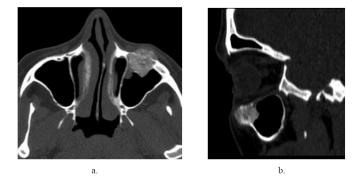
(case 5). 51-year-old female patient with intraosseous hemangioma. (a) Axial and (b) sagittal paranasal sinus computed tomography on the anterior wall of the left maxillary sinus small expansile lesion with thickened vertical trabeculation giving the "polka-dot appearance".
